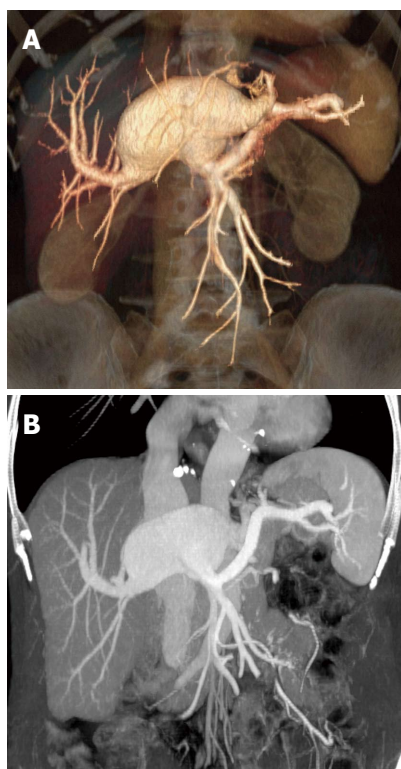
Computed tomography. A: Volume rendering reconstruction of the aneurysm; B: Maximum intensity projection of the aneurysm.
